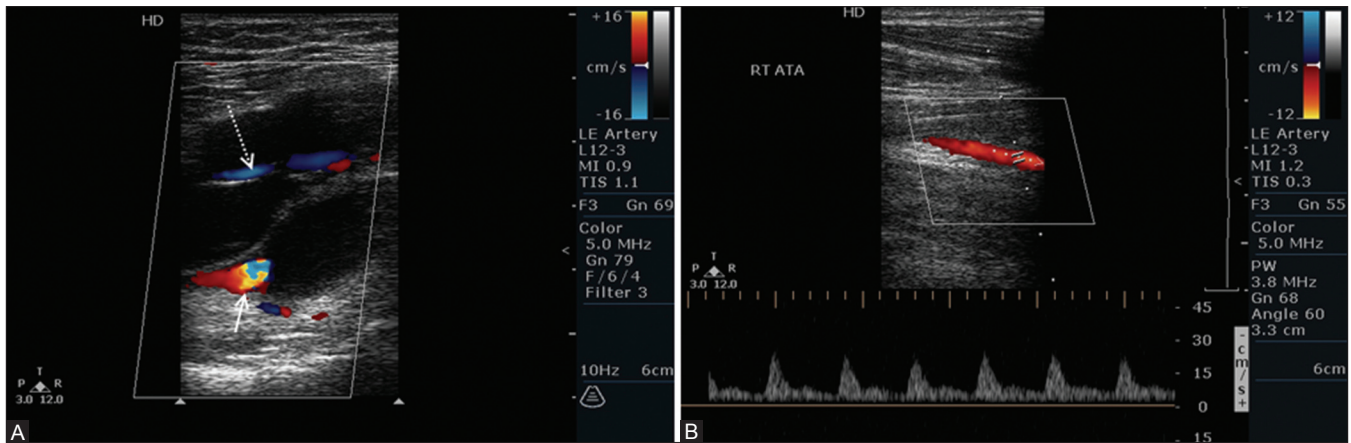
(A, B): (A) Color doppler image showing multilocular cystic lesion with no internal flow in the popliteal region causing narrowing of popliteal artery (white arrow) and vein (dotted white arrow). (B) Spectral doppler image shows dampened low resistance flow in right anterior tibial artery
